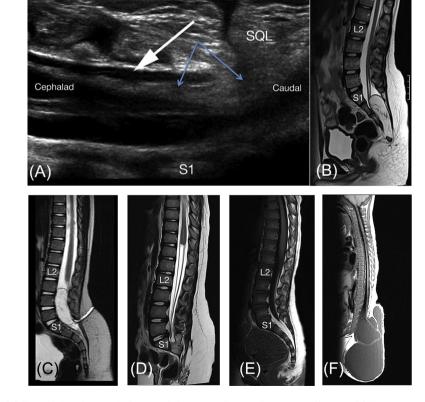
Imaging of OSD. (A) Lumbosacral ultrasound demonstrating a subcutaneous lipoma (SQL) connected to an intradural mass (arrow); (B) MRI demonstrating lipomyelomeningocele and low conus; (C) MRI of dermal sinus track with intradural dermoid mass; (D) MRI of caudal regression syndrome with a typical squared appearance of the conus, which is higher than normal; (E) MRI of fatty infiltration of filum terminale; and (F) MRI of myelocystocele
